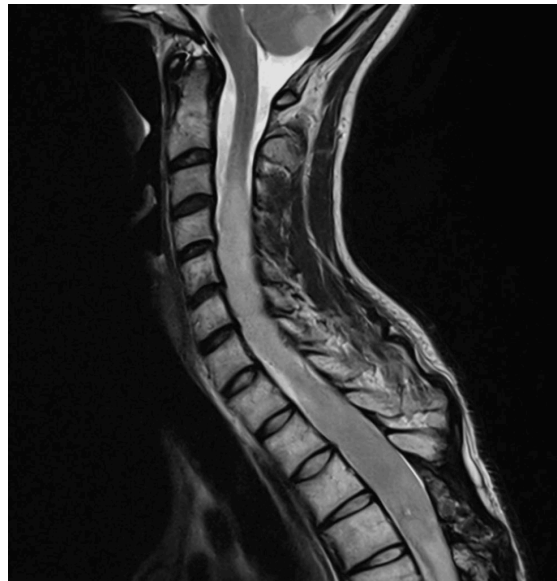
Sagittal T2-weighted MRI of the cervical and upper thoracic spine demonstrating marked intramedullary expansion with diffuse T2 hyperintensity extending longitudinally from the cervical region into the thoracic cord. The spinal cord appears enlarged and infiltrated, consistent with an extensive diffuse midline glioma.
